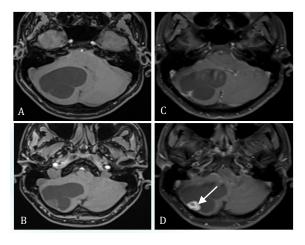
MRI axial sections at the level of cerebellum (A&B) T1 pre-contrast VIBE sequence and (C&D) T1-FS post contrast imaging, there is avid heterogeneous enhancement of the eccentric solid mural nodule (white arrow) and minimal enhancement of septations.
